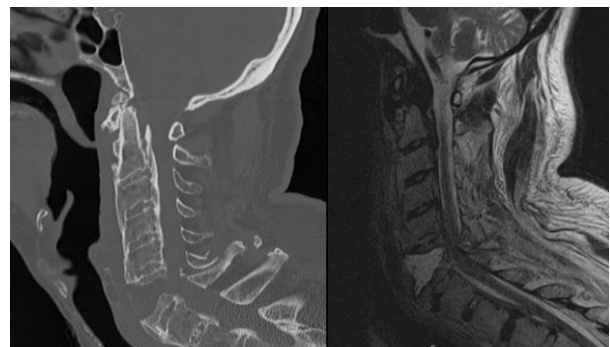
A. Preoperative cervical CT and MRI: C6 transomatic fracture.
